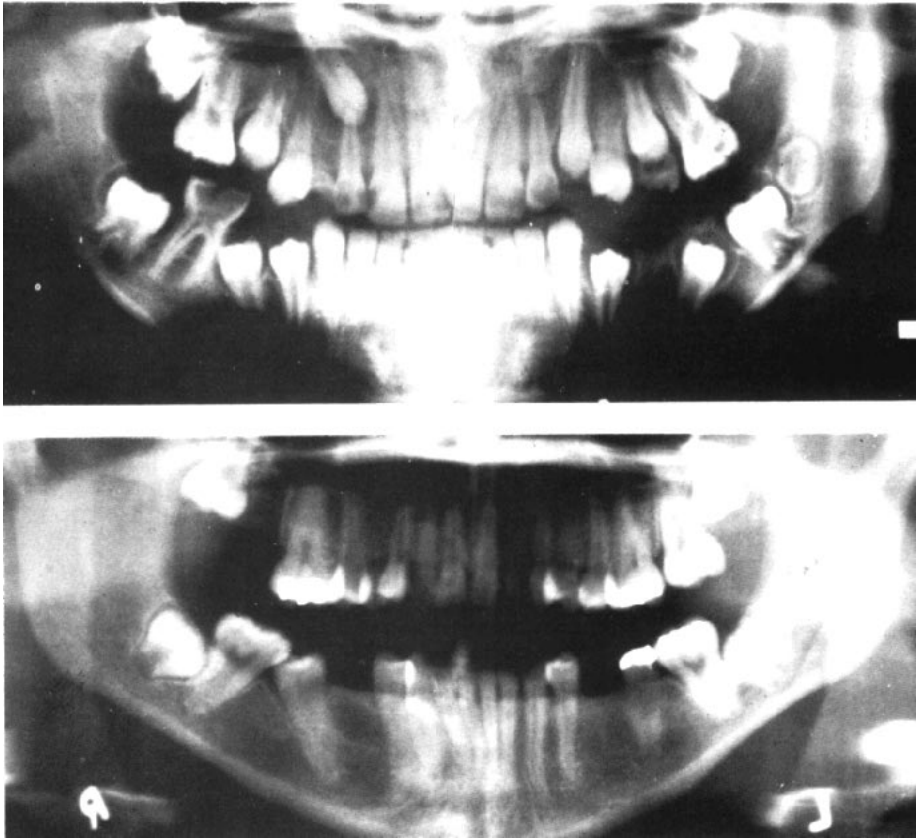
(a) Panoramic radiograph of patient showing migration of lower left second bicuspid into first molar space. (b) Panoramic radiograph of patient with migration of erupting lower second bicuspids into first molar spaces.
